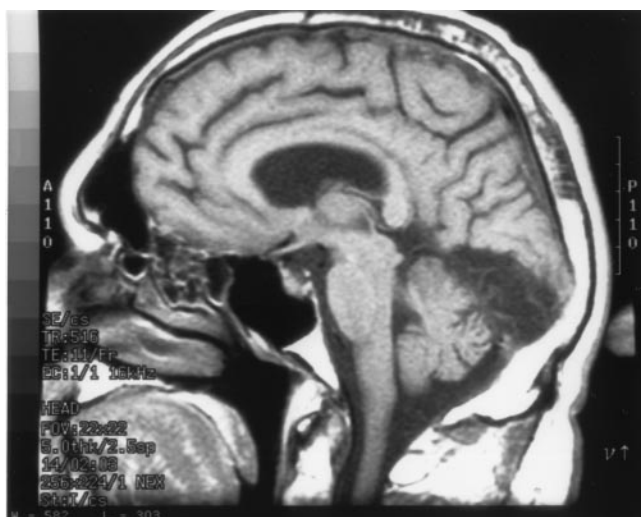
Sagittal T1-weighted MR image of patient 11 showing an infarct in the left inferior occipital cortex, with no involvement of the cortex superiorly.
